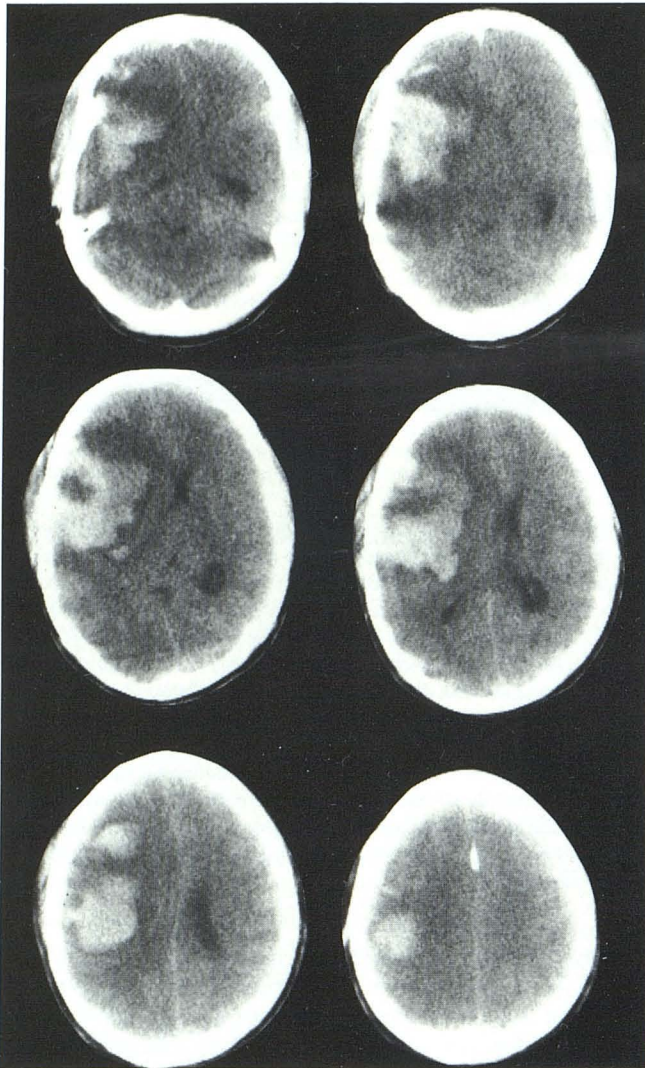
Initial CT study. Right hemispheric intracerebral hematoma on six successive slices.
